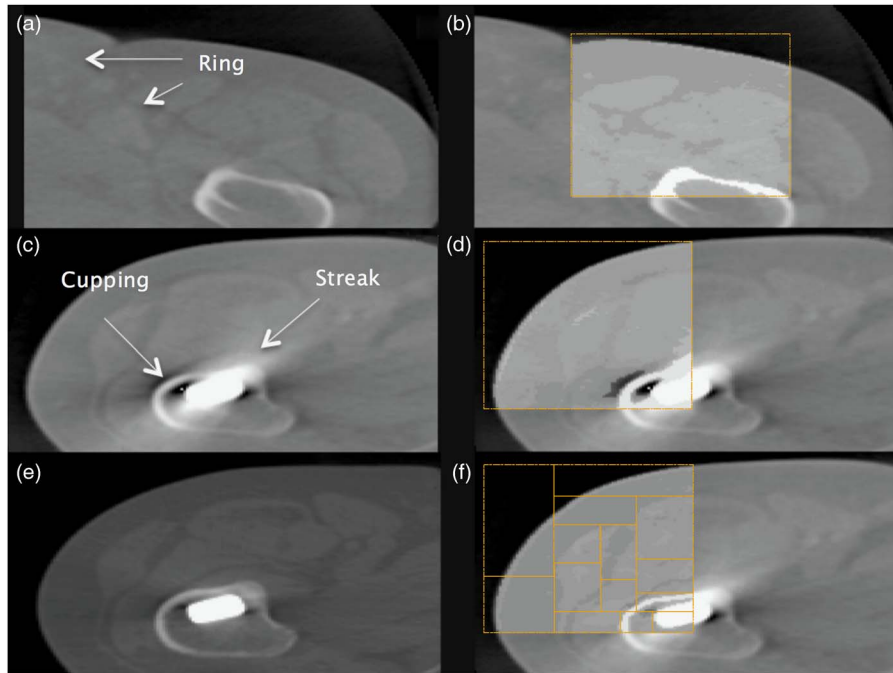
Two different locations and slices of the original cone beam computed tomography (a and c) and the resultant images after segmentation using the same threshold values in only a part of the image (b and d, respectively). In particular it is observed in (d) that the artefacts in the vicinity of the metal are erroneously corrected. Variable threshold values were then used (f), which compared well with the original planning computed tomography image (e).
